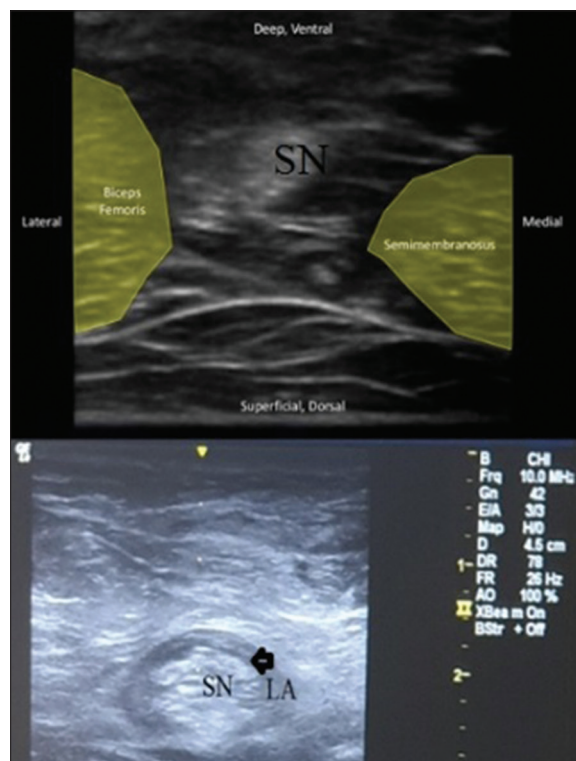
Ultrasound image of Sciatic nerve before bifurcation above the level of popliteal fossa and spread of local anaesthetic around the nerve following injection (Indicated by arrow). SN- Sciatic nerve, LA- local anaesthetic agent
